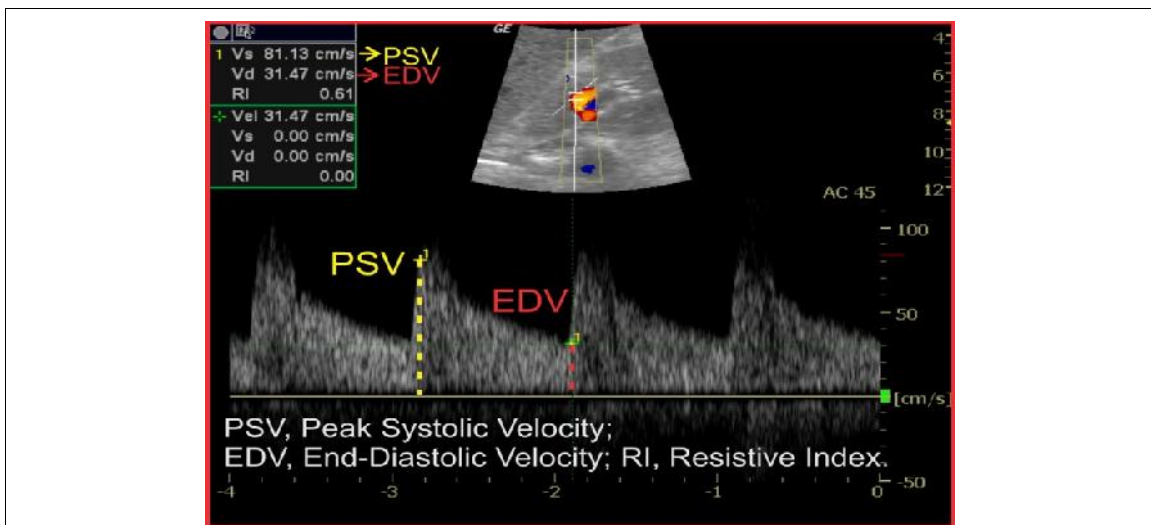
Doppler parameter (PSV, EDV, and RI) measurement technique.
